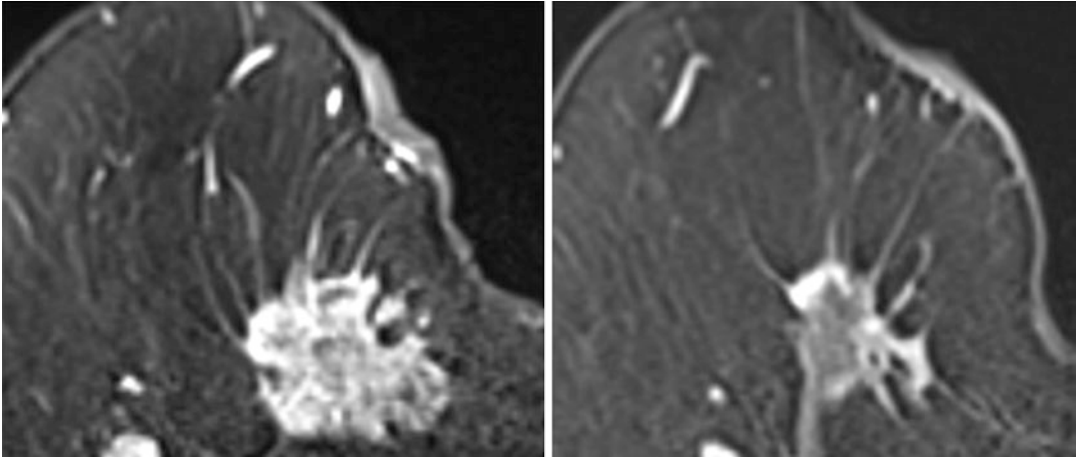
Typical changes of treatment response in breast cancer on contrast-enhanced MRI. Contrast-enhanced MRI of breast cancer before (Left) and after (Right) chemotherapy. There was an oval-shaped mass with spiculated margin in the right inner area of the breast (Left).
